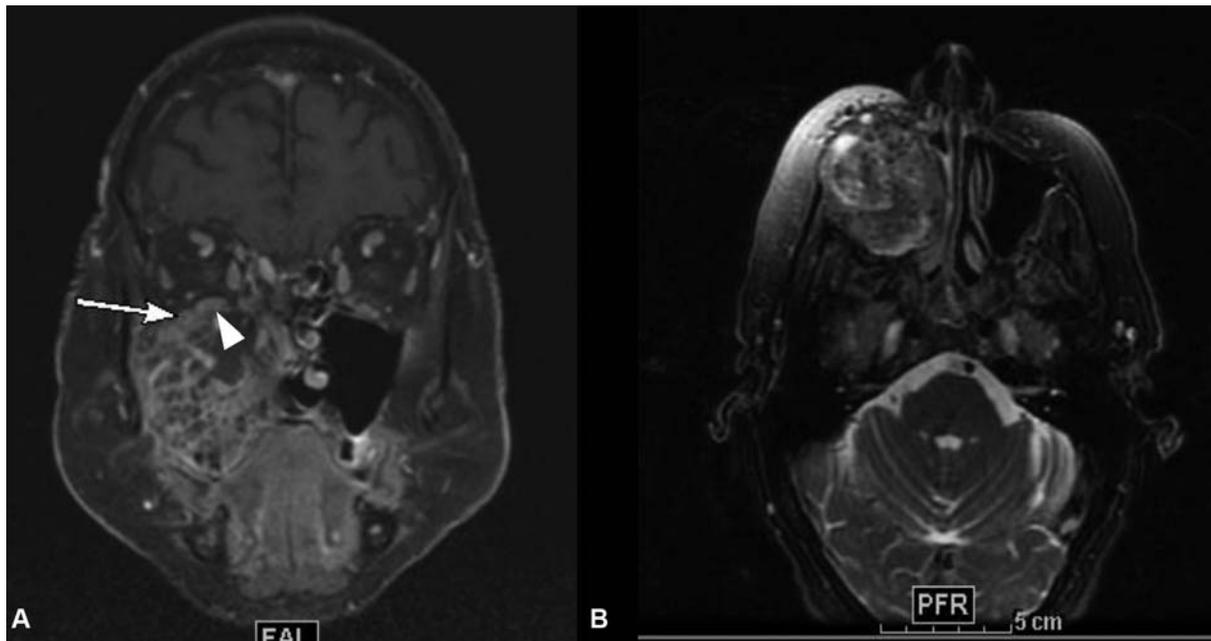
(A, B) Coronal T1 and axial T2 contrast-enhanced MRI demonstrating a mass centered in the right maxillary sinus (arrow). There is likely erosion of the orbital floor; however, there is no clear invasion of the inferior rectus (arrowhead). MRI, magnetic resonance imaging.
